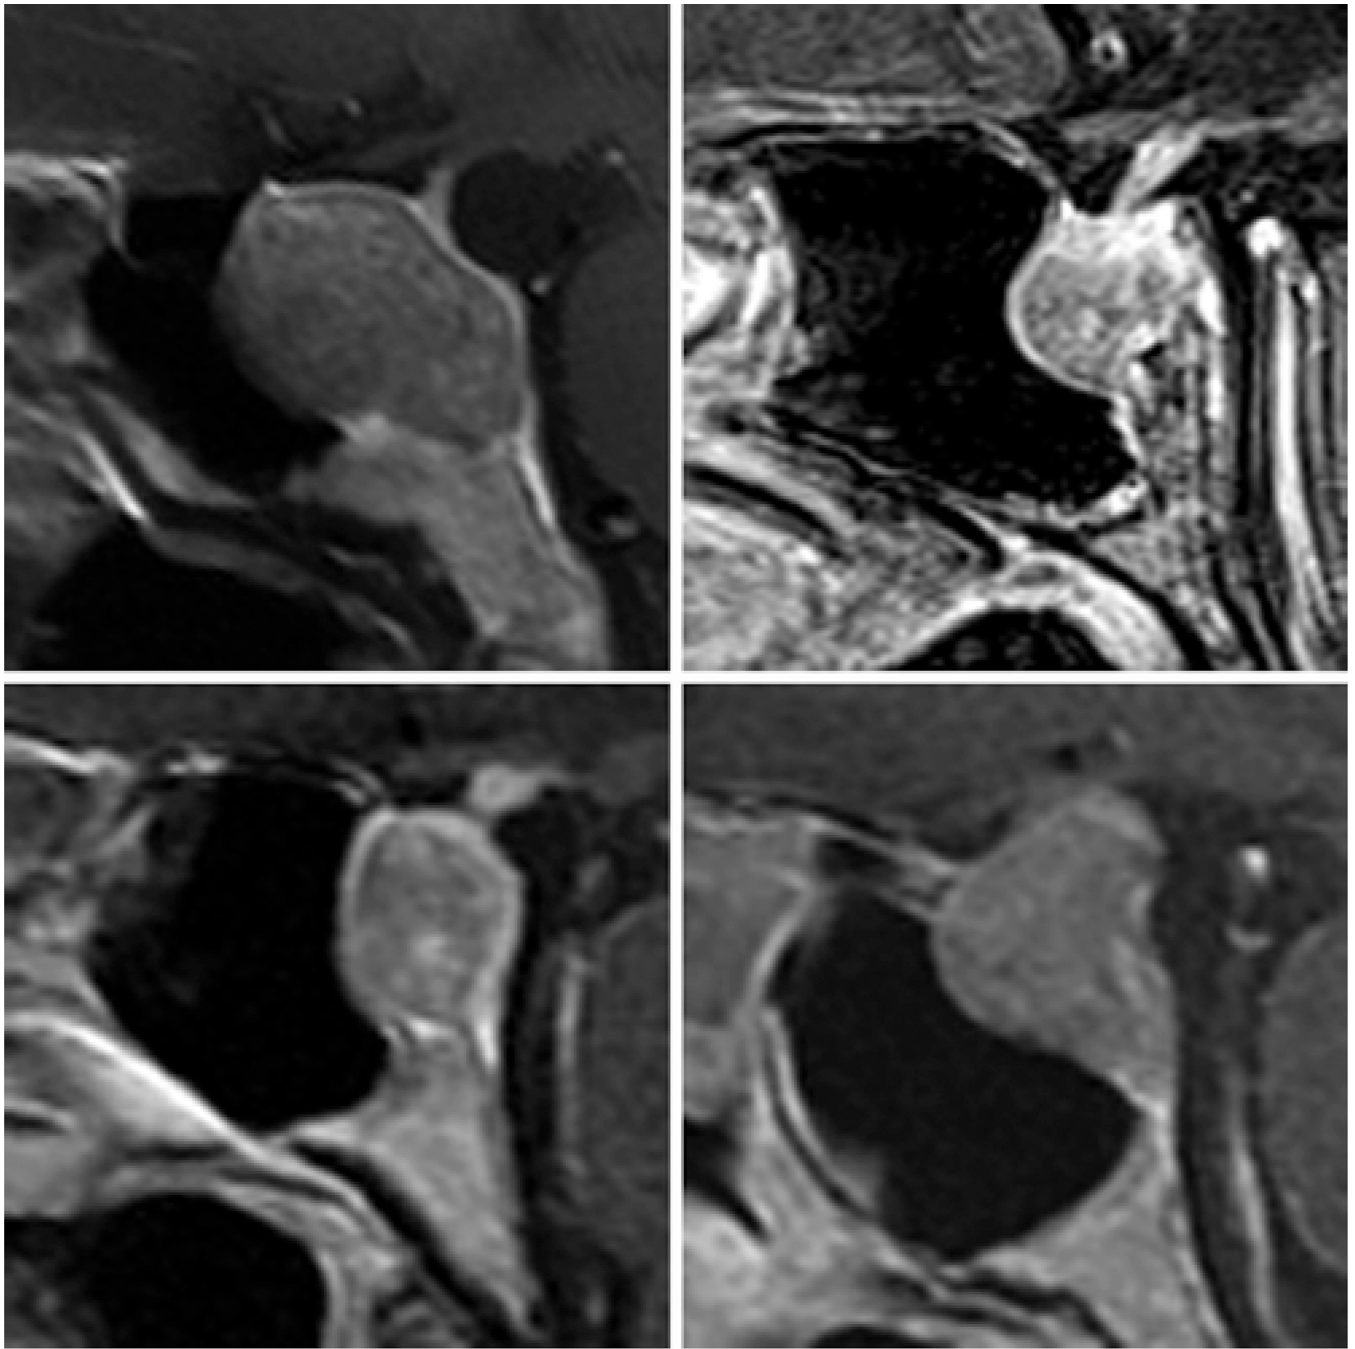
Sagittal MR images obtained in 4 patients with pituitary adenomas and clival erosion without obvious erosion of the sellar floor.
